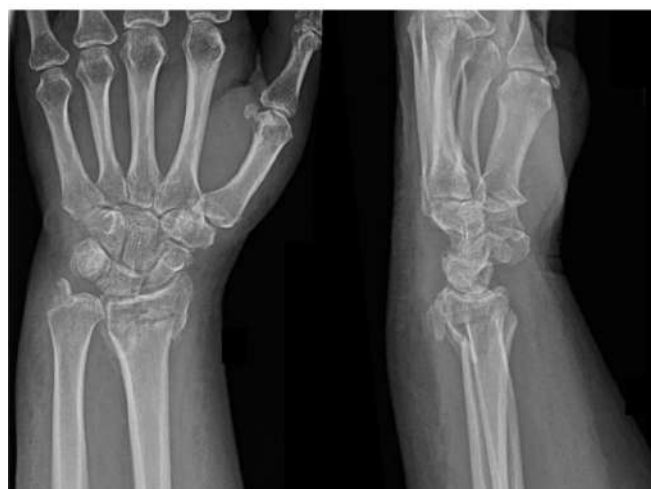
X-ray imaging after removal of plaster fixation and start of rehabilitation (5 weeks after repositioning)
